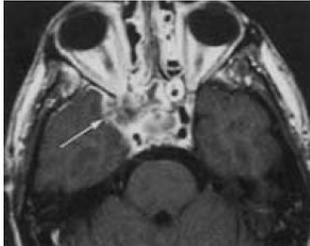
MRI brain & orbit (axial post contrast) image showing diffuse inflammatory changes involving ethmoid and sphenoid sinus, extending in to apex of the of right orbit, & in right middle cranial fossa with the involvement of right cavernous sinus.
